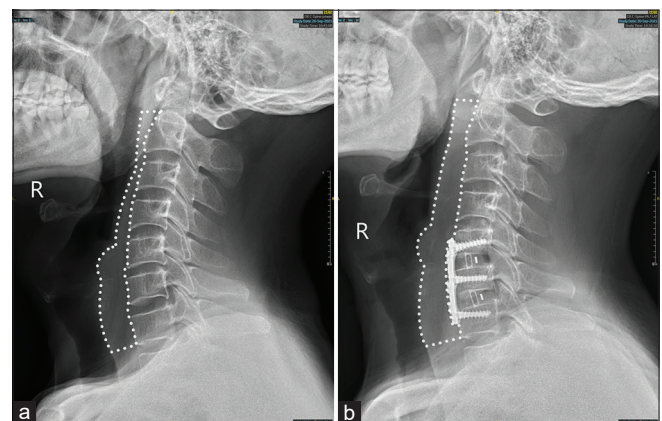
The area of soft tissue on the anterior edge of the C2-7 vertebral body on lateral radiographs before (a) and after surgery (b)
